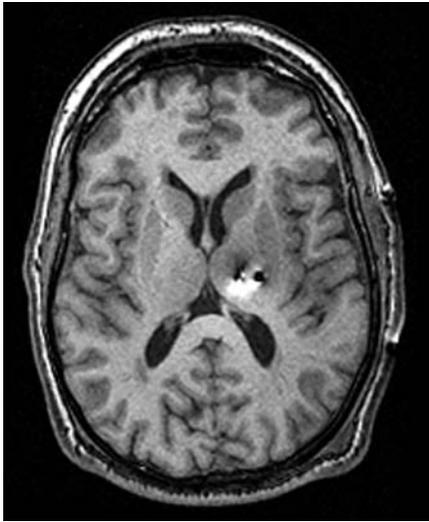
Postoperative MRI. This T2-weighted MRI scan shows the contact visible as a circular low density in the sensory thalamus (laterally). The wire leading to the lower PVG electrode can be seen medially.
